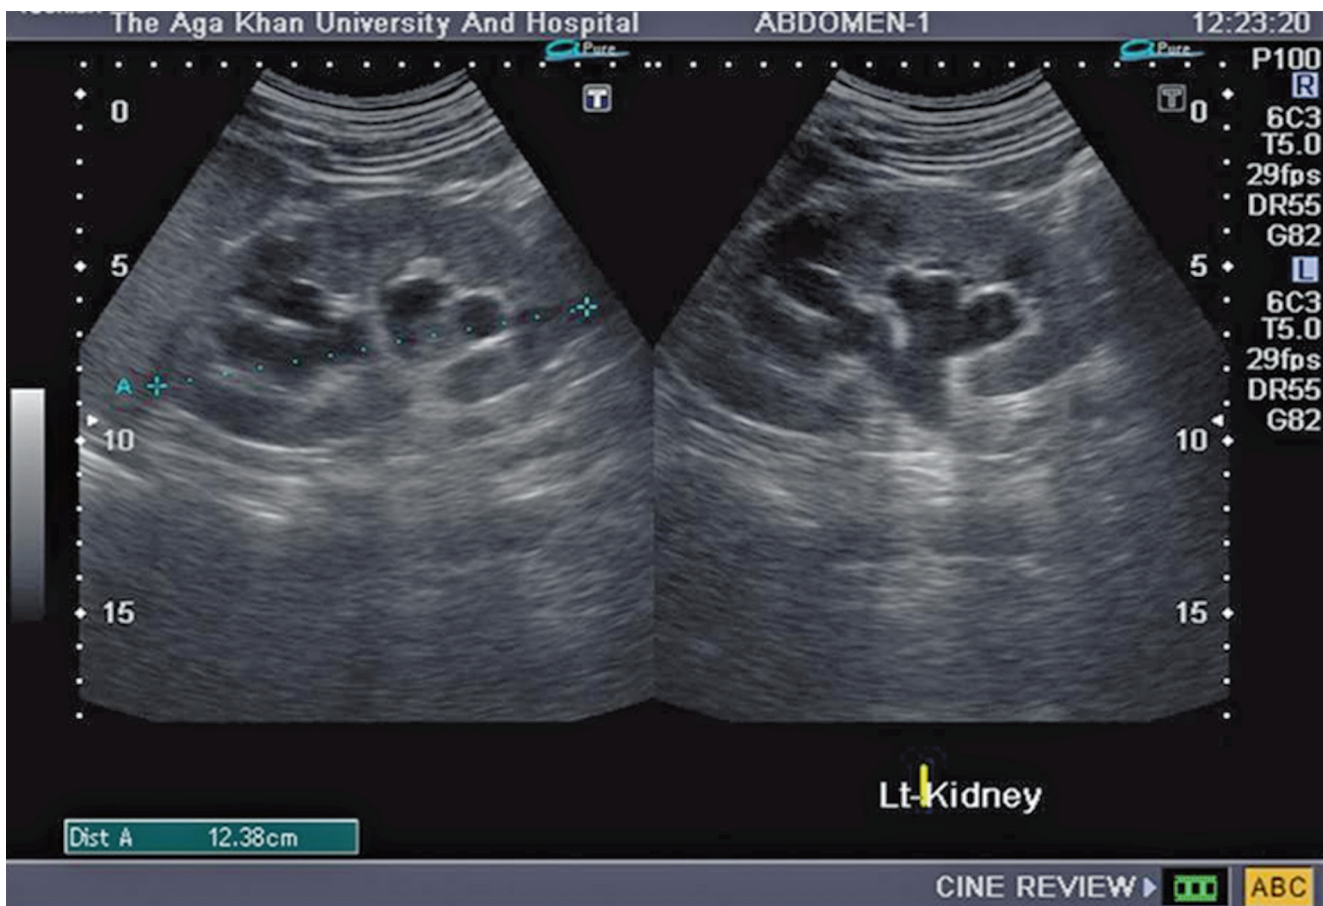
Ultrasound indicating ureteral stone
